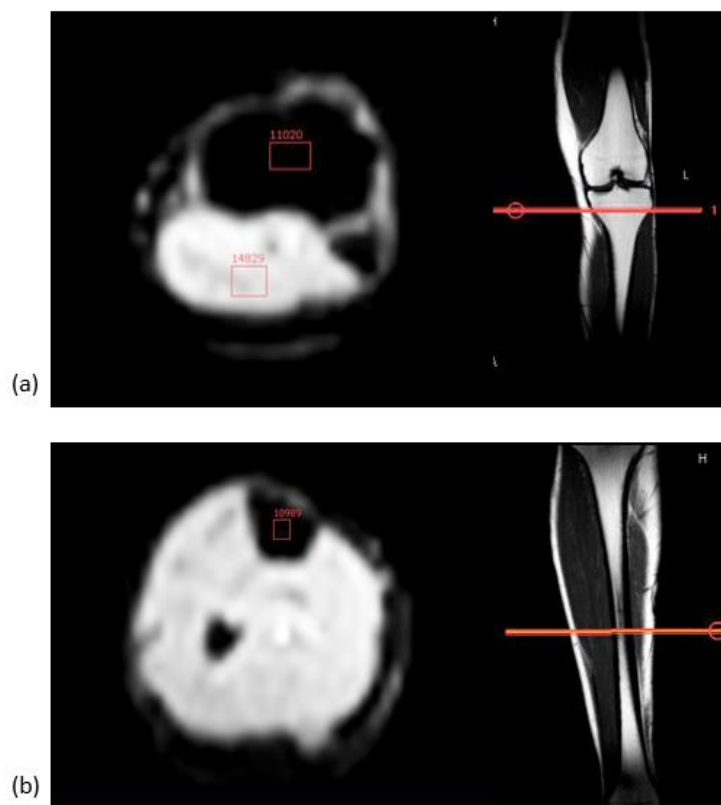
Example ROI placement of (a) the proximal tibia and (b) the tibial diaphysis for time-signal analysis during the BOLD MRI arterial occlusion protocol.
